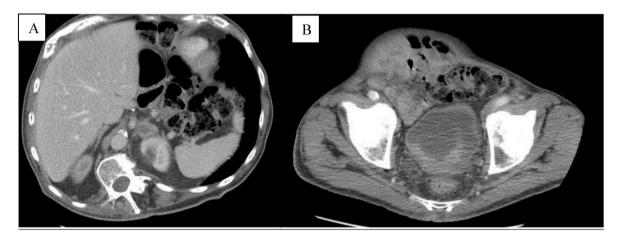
CT abdomen and pelvis demonstrating left adrenal lesion (A) and irregular thickening of the urinary bladder (B).
